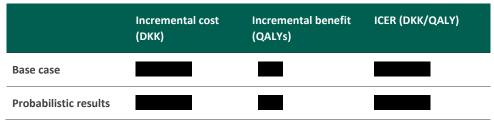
Abbreviations: AE: Adverse event, BSC: Best-supportive care, CT: Computed tomography, DKK: Danish Crowns, ICER: Incremental cost-effectiveness ratio, OS,: Overall survival, PF: Progression free, PD: Progressed disease, PFS: Progression-free survival; QALY: Quality adjusted life years, RDI: Relative dose intensity, TTD: Time to discontinuation
